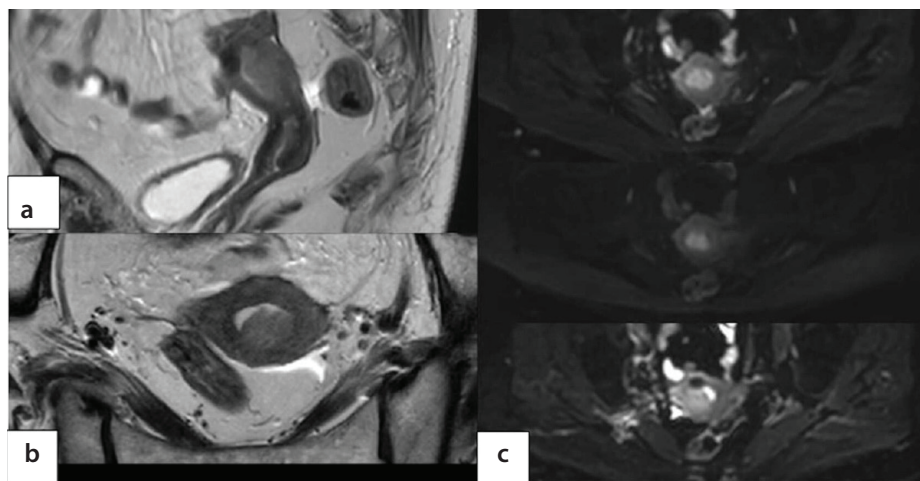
In a 64-year-old patient with a pathological diagnosis of high-grade mixed carcinoma, a mildly hyperintense endometrial mass lesion is observed on T2-weighted sagittal (a) and oblique axial (b) series, and it appears as a high signal intensity lesion on diffusion-weighted imaging (c). Based on the MRI examination, the lesion was concluded not to exhibit DMI. However, pathological evaluation confirmed DMI. No specific factors were identified on MRI that could explain the incorrect assessment. MRI, magnetic resonance imaging; DMI, deep myometrial invasion.
